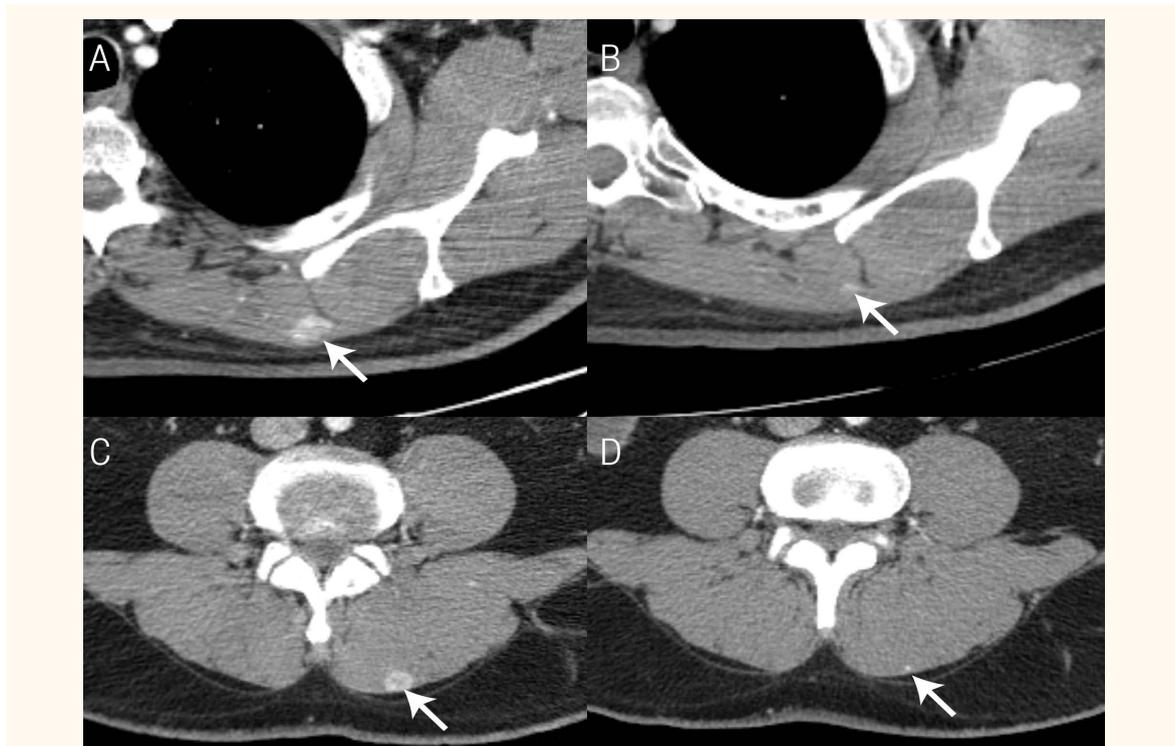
Enhanced computed tomography (CT) images of a 58-year-old man with renal cell carcinoma. A: Initial detection and reporting of a left *trapezius* metastasis measuring 14 x 11 mm (arrow). B: The same metastasis was subtler and less well-defined yet still visible 11 months earlier (arrow). This lesion had a heterogeneous pattern of enhancement. C: Initial detection and reporting of a left paraspinal metastasis measuring 10 x 9 mm (arrow). D: The same metastasis was much smaller although still visible 11 months earlier (arrow). This lesion had a homogeneous pattern of enhancement when first visible which became peripheral later. Both muscle metastases appeared oval when they were first detected in cross-sectional imaging.
